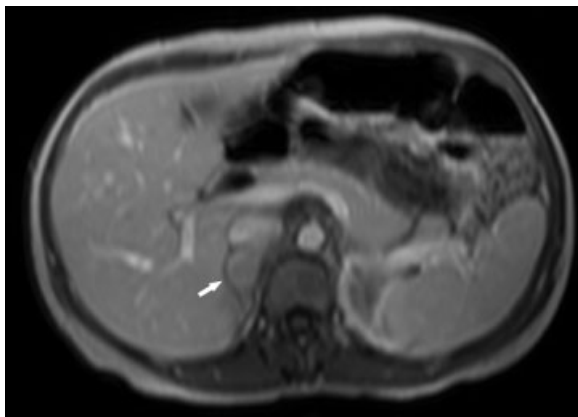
T1-weighted postgadolinium axial magnetic resonance imaging depicting a large soft tissue mass of the right adrenal gland (arrow).
